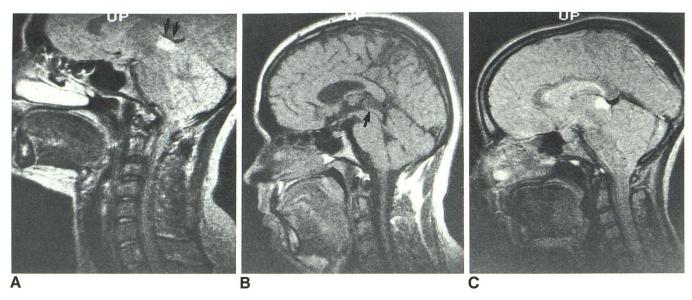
A, T2-weighted image at 0.5 T. Large pineal cyst appears to indent inferior wall of vein of Galen (arrows). B and C, Another patient. Superior
